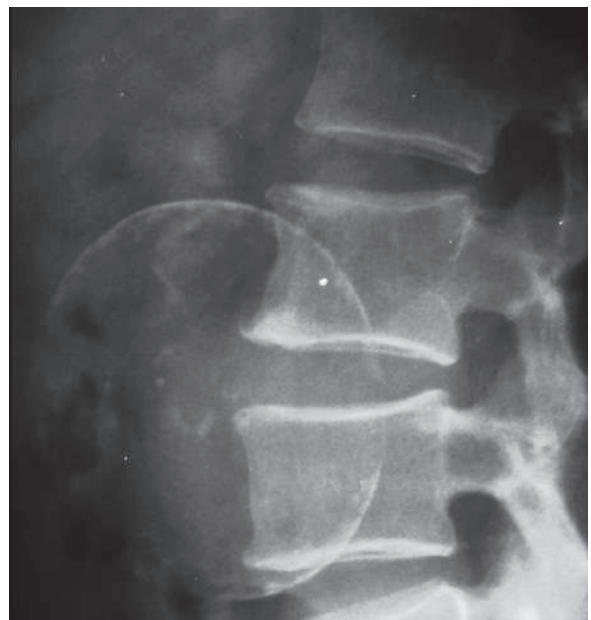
Lateral plain radiograph of the thoracic spine shows a calcified hydatid cyst in the paraspinal region
